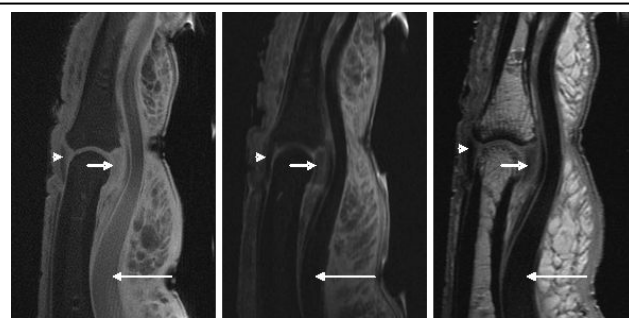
Sagittal UTE imaging of the finger with fat saturation shows high signal in the volar plate (short arrow), flexor digitorum profundus tendon (long arrow), and dorsal extensor tendon (arrow head) compared to PD-weighted FS FSE imaging (middle) and T1-weighted FSE imaging (right).
